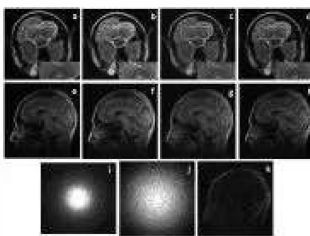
Visual quality comparison: (a) and (e) Reference images, (b) and (f) Zero-filled MR images, (c) and (g) Image prediction from the network, (d) and (h) Reconstructed results, (i) the 5x-acceleration mask for the transversal brain, (j) the 3x-acceleration mask for the sagittal brain, and (k) reconstruction error of the sagittal brain
